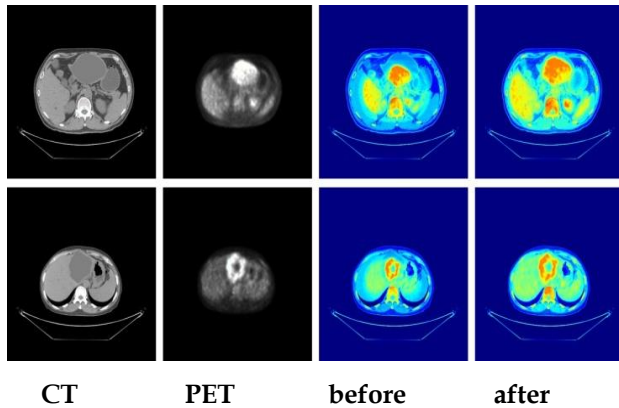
Visual comparison of the results obtained by affine alignment compared to the original PET-CT fusion image. The first two columns show original CT images and PET images, the following two columns show the fusion results of original PET-CT pairs and results after affine alignment.
